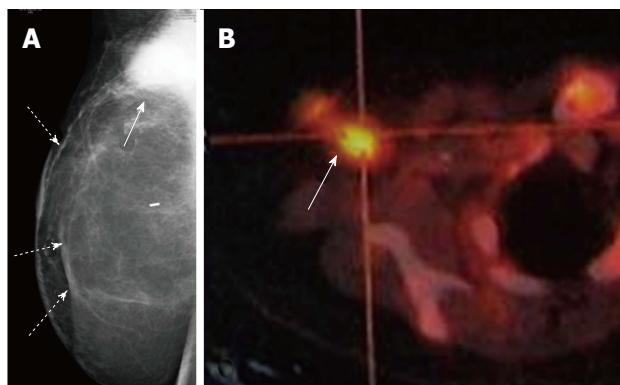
Patient underwent right skin sparing mastectomy with Deep Inferior Epigastric Perforator Flap (dashed arrows in A) and axillary and apical clearance, one year later she presented with right axillary nodes (arrow) on mammogram (A) which were FDG-avid on PET (B).
